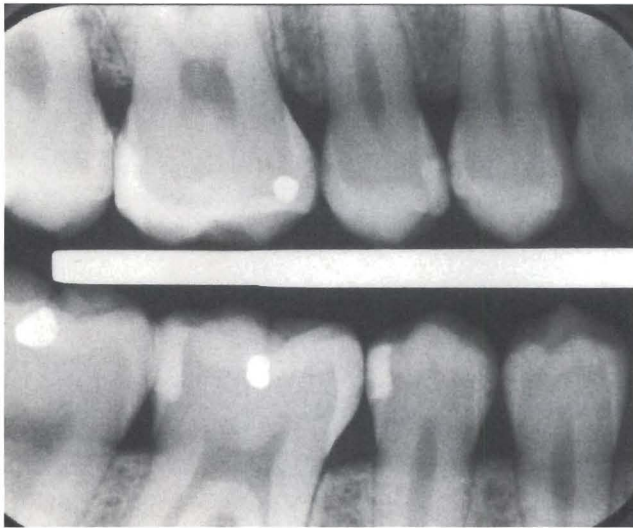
Radiograph of a box-only restoration in tooth 45.
